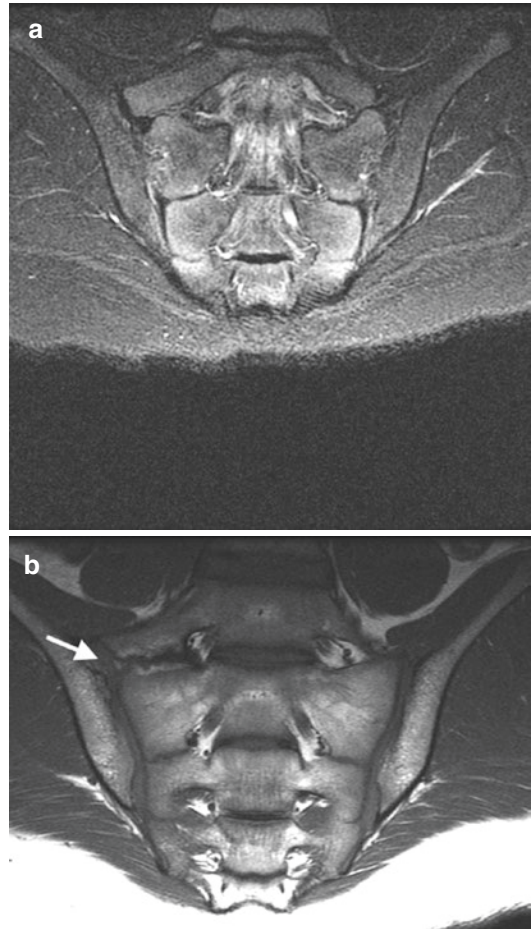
MRI transitional vertebra type 2 b in a symptomatic 15-year-old female elite gymnast with Bertolotti syndrome: (a) no osteitis demonstrated on Cor T2FS; (b) Cor T1 does demonstrate cortical irregularity and post-inflammatory fat accentuation at right synchondrosis (*arrow*)
